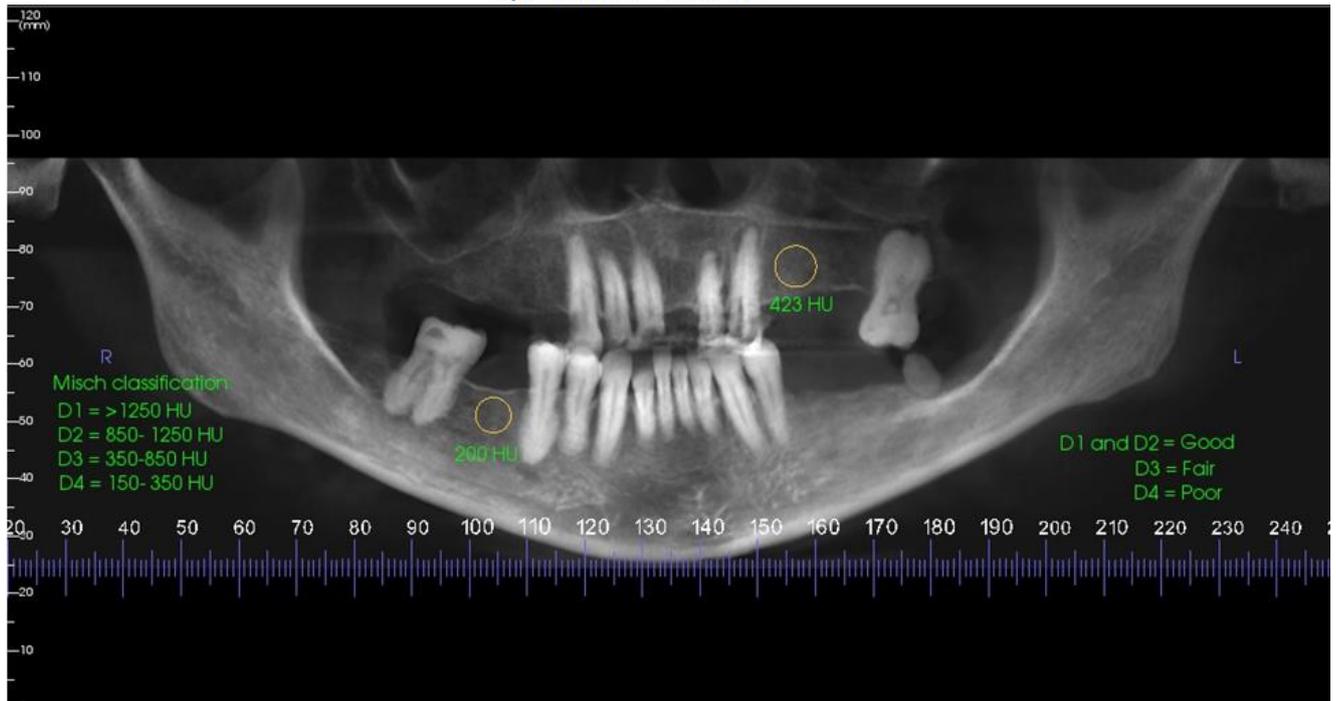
CBCT image depicting bone mineral density in Hounsfield units (HU) at 2 different sites on the maxilla and mandible respectively, along with Misch classification and its interpretation of bone quality
